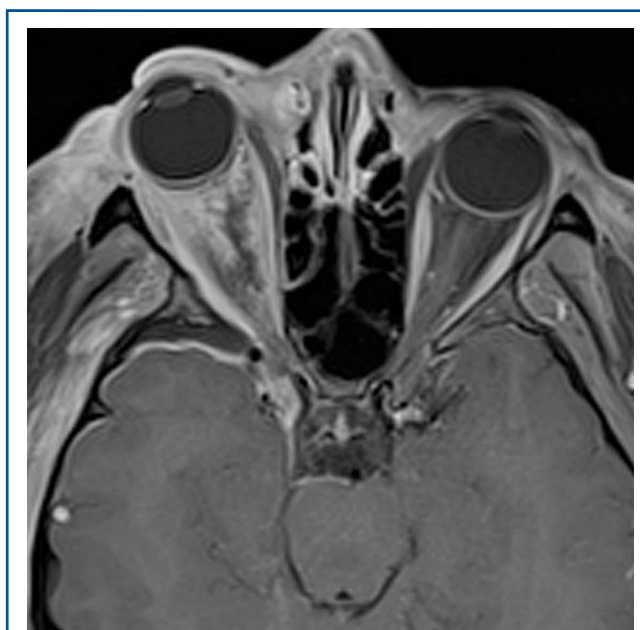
Postoperative axial T1-weighted MRI of the brain with gadolinium enhancement demonstrating complete resection of the optic nerve lesion. Only extraocular muscles remain as shown.
